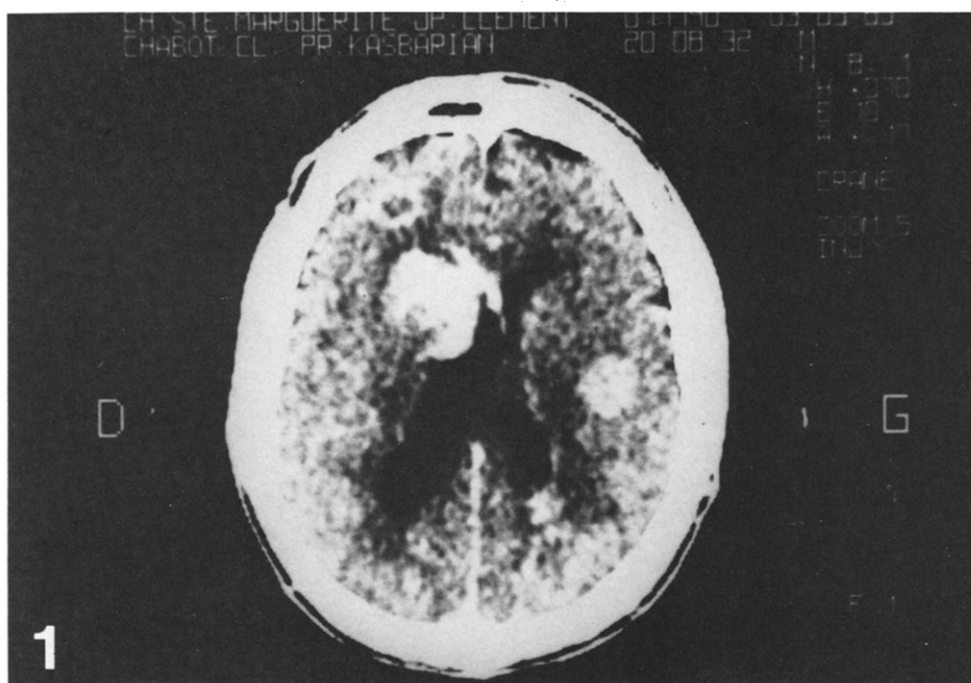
Cerebral CT scan before chemotherapy.
